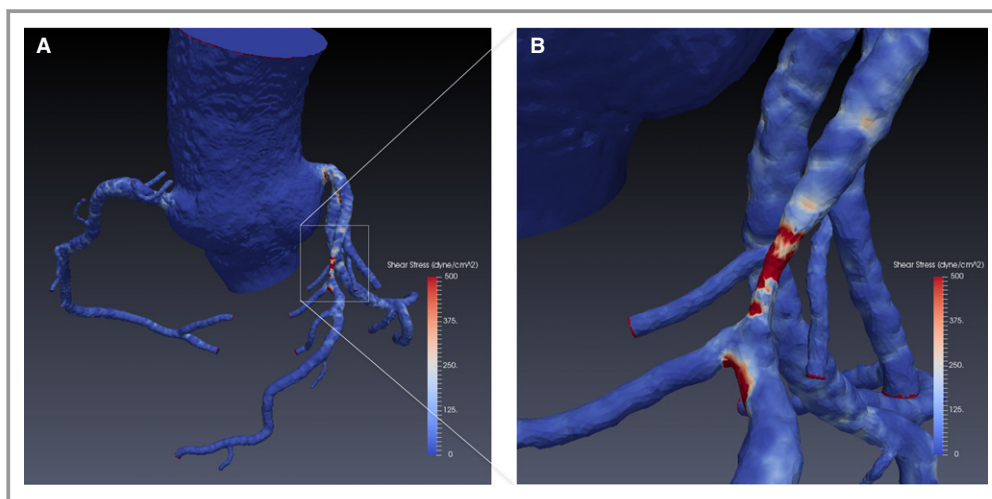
A, Color-encoded wall shear stress based on a 3-dimensional model by coronary computed tomography angiography. B, Zoomed image for coronary atherosclerotic lesion.
